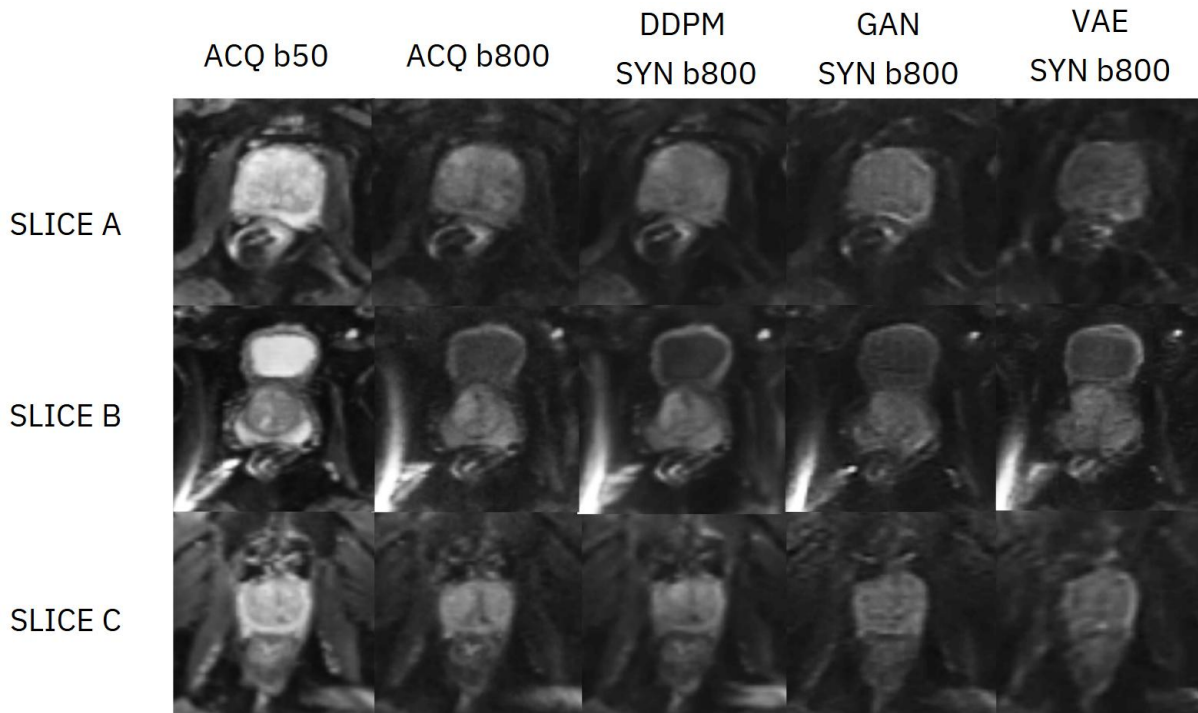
Comparative visualization of DWI for three randomly selected prostate slices (SLICE A, B and C) of the validation set of the PROSTATEx database. The sequence includes the acquired low b-value DWI (ACQ b50), the acquired high b-value DWI (ACQ b800), and the synthetic high b-value DWIs generated by the DDPM (DDPM SYN b800), GAN (GAN SYN b800), and VAE (VAE SYN b800).
